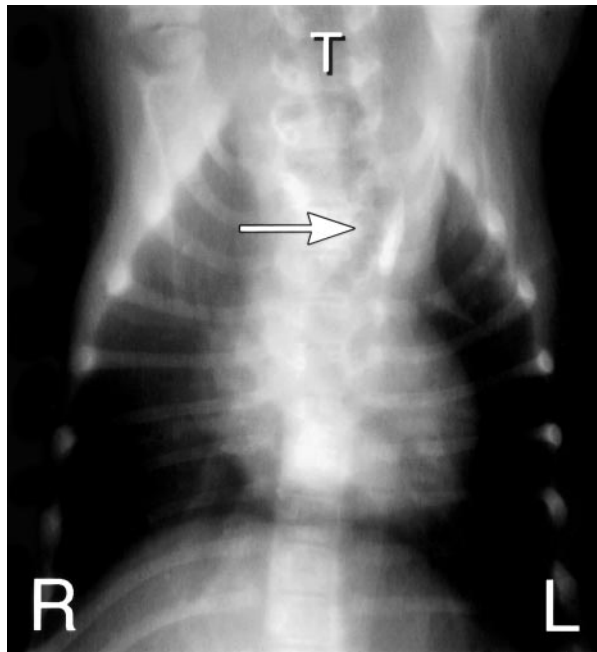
Ventrordorsal radiograph of a 10-week-old Golden Retriever with persistent right aortic arch confirmed at surgery. The trachea (T) is curved leftward more than 100% of the tracheal diameter near the cranial border of the heart (arrow) and is narrowed more than 25% in the deviated segment.
